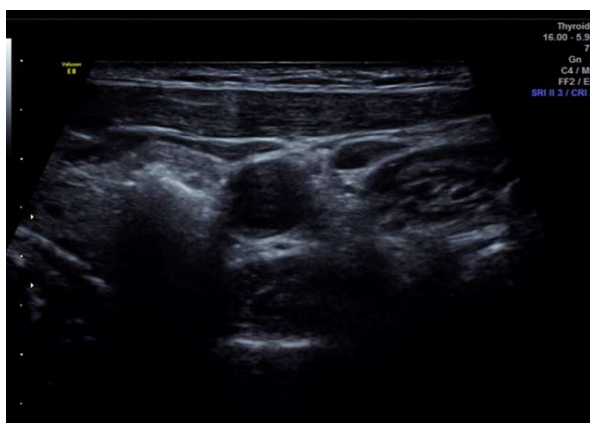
Ultrasound image of microwave ablation of thyroid tumors.
